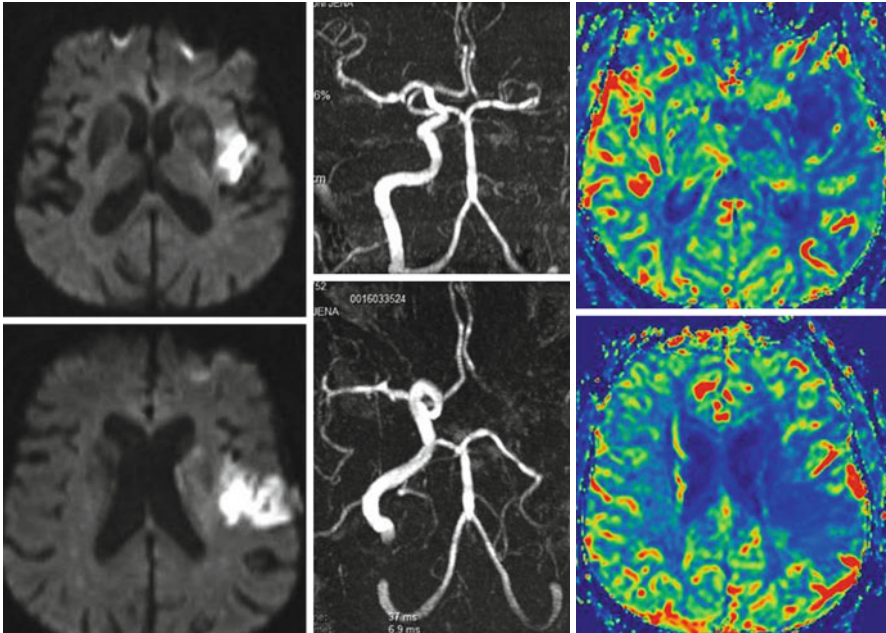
Typical set of MRI images of an ischemic infarct of the left middle cerebral artery (MCA) territory: signal increase on the DWI images (*left panel*); corresponding MR angiography showing an occlusion of the left MCA (*middle panel*); perfusion deficits in the left MCA territory (*right panel*)
